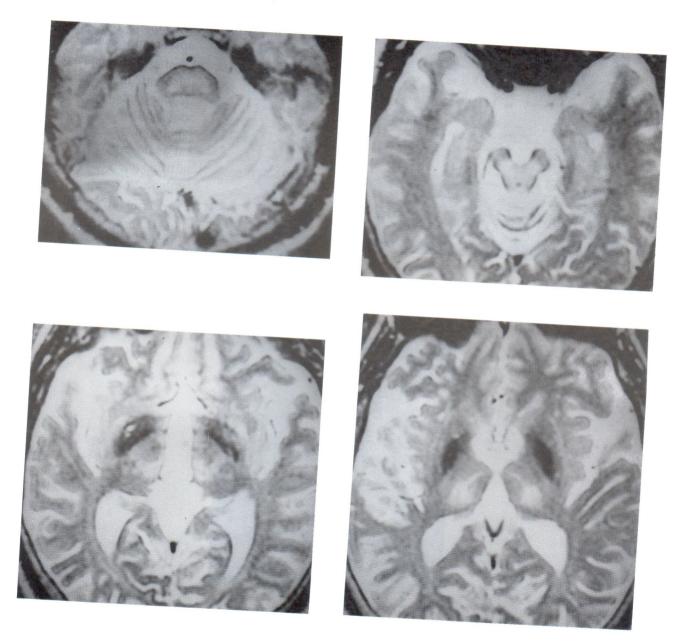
Case 2. T2WI axial MRI of the brain showed bright signal at pons, thalami and midbrain.
